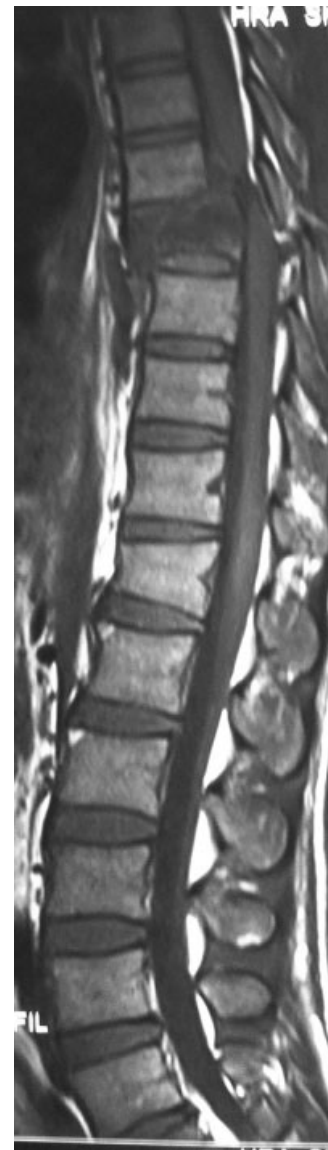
MRI of the spine sagittal section shows fracture-subluxation of midthoracic vertebra.
